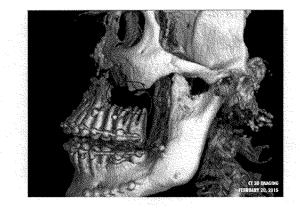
Left Side Full Volume CBCT Scan View. Note bone damage and loss due to poor surgical technique and an extremely invasive procedure conducted by an inexperienced/unqualified surgeon.
